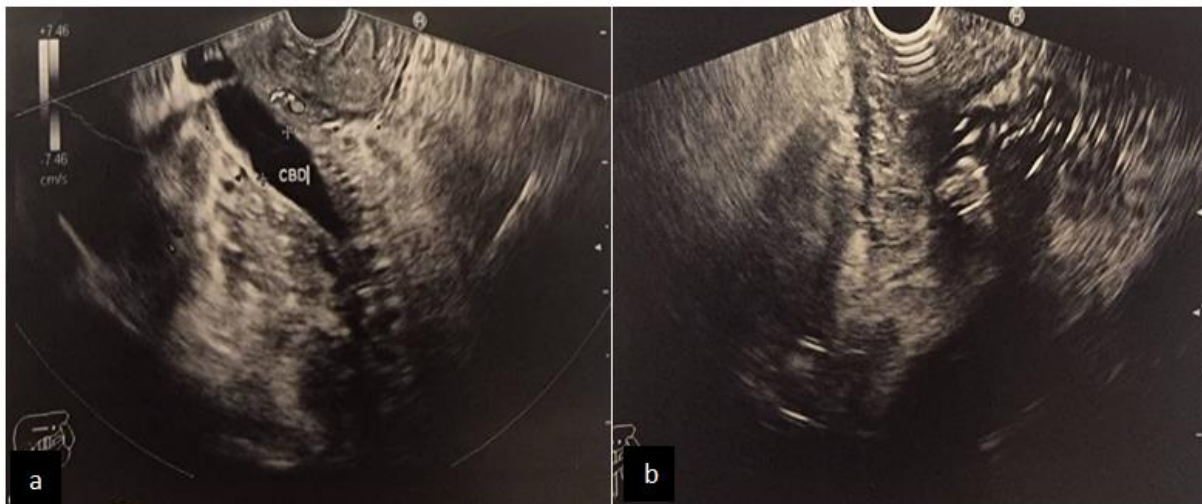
Endoscopic ultrasonography showing: a) Dilated common bile duct due to compression by diverticulum; b) Water along with air bubbles (echogenic foci) moving from the duodenal lumen into the diverticulum
